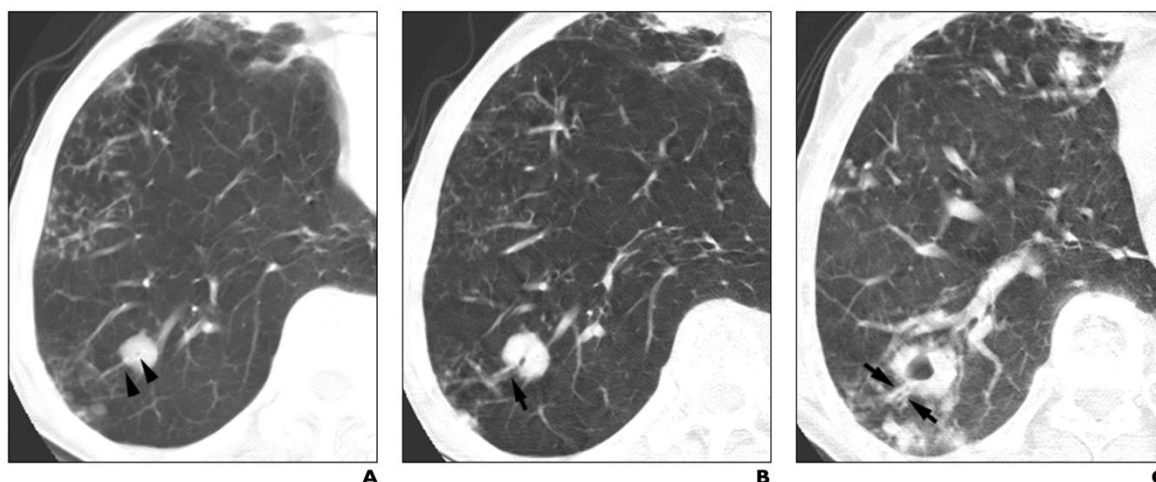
Serial CT images showing cavitation formation in nontuberculous mycobacterial (NTM) infection caused by *Mycobacterium avium–intracellulare* complex. (A) Peribronchial nodule in the right lower lobe; arrowhead indicates a central bronchiole appearing as a radiolucent area. (B) Six-month follow-up CT shows enlargement of the nodule with a central bronchiole extending toward the peripheral lung. (C) Twelve-month follow-up CT demonstrates a peribronchial nodule with focal cystic bronchiectasis, presenting as a large cavitary lesion. (Source: Ryu, 2016)
